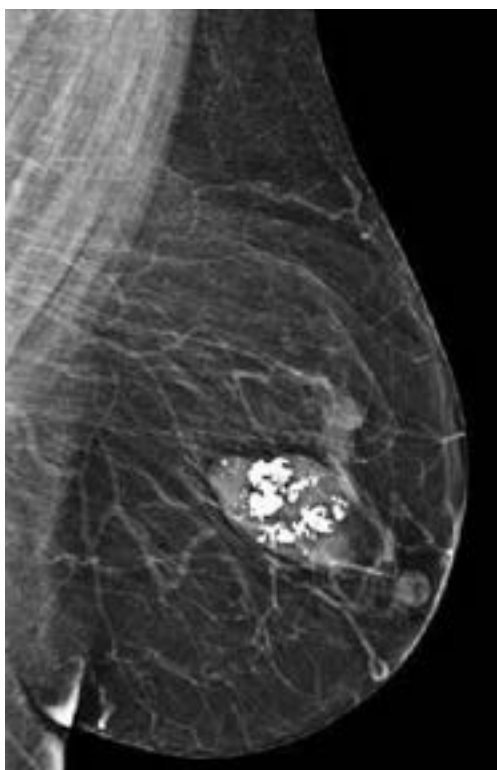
MRI breast showing popcorn image of fibroadenoma breast.
